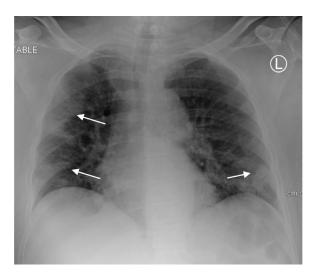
Frontal chest radiograph demonestrates peripheral multifocal opacities at the right middle and lower lung zones bilaterally.
